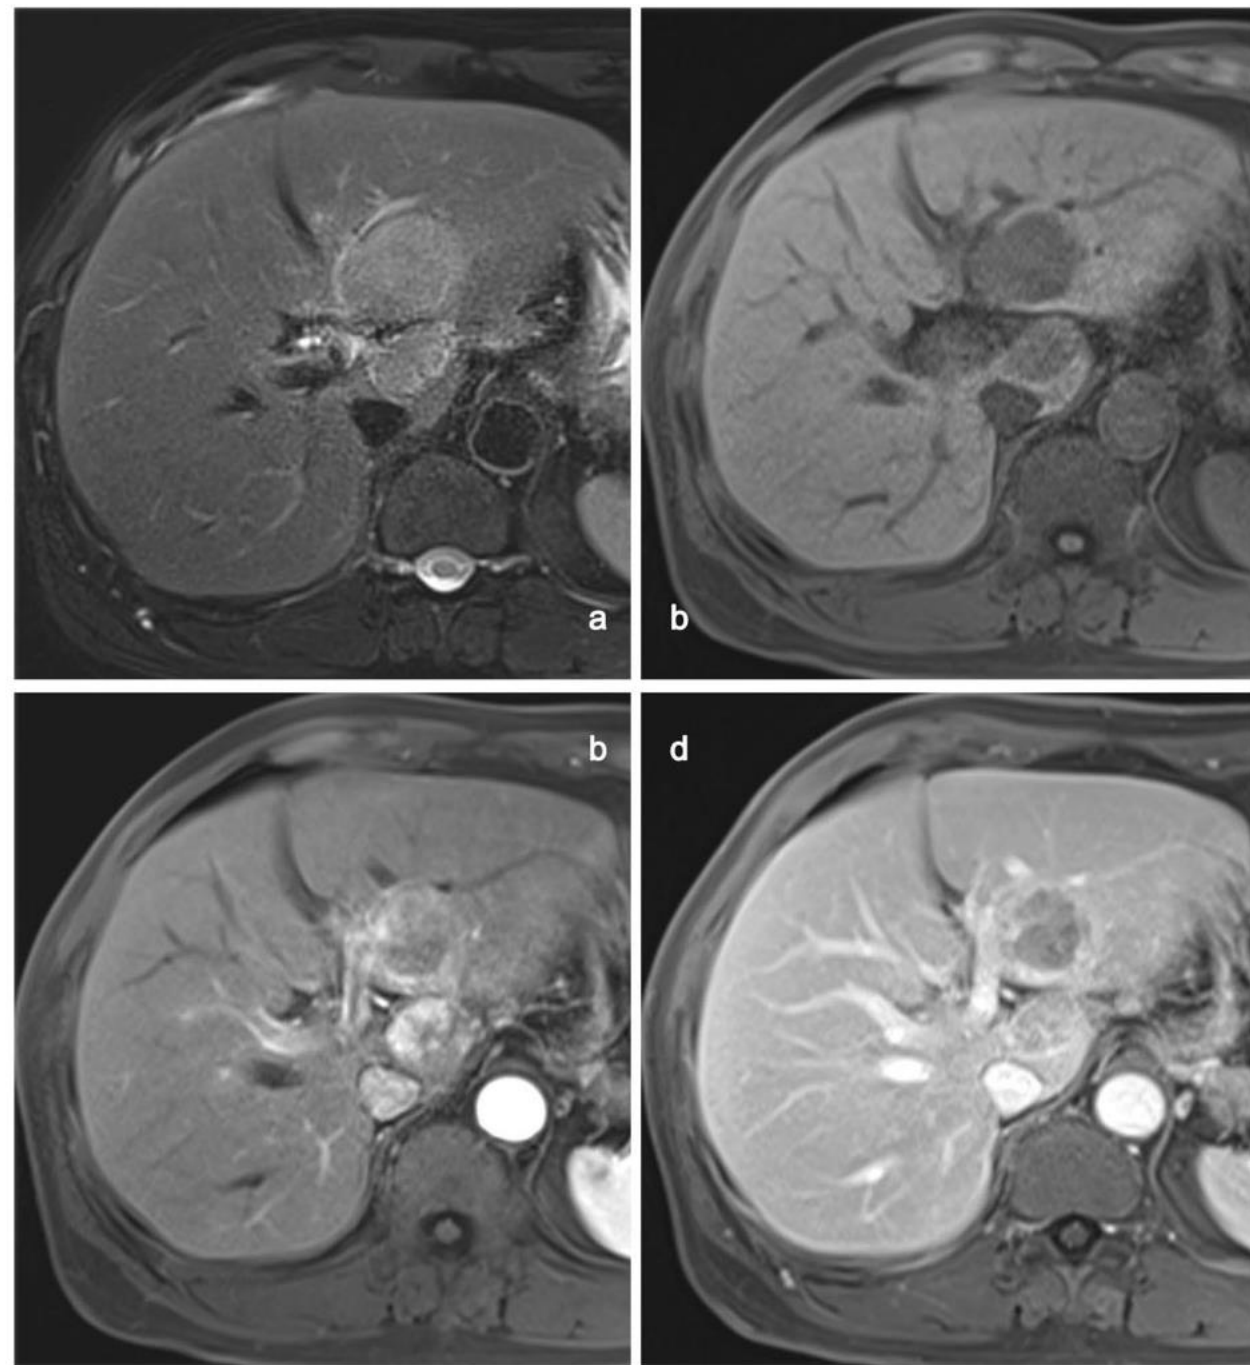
MR images in a 68-year-old man with classical ICC. Axial a T2-weighted, b precontrast T1-weighted, c arterial phase, and d portal phase gadolinium-enhanced MRI scans. Tumor (longest-diameter, 23 mm) with a lobulated margin exhibits hyperintensity on T2-weighted image (a), hypointensity on pre-contrast T1-weighted image (b), rim hyperenhancement on arterial phase image (c), and persistent enhancement on portal phase image (d). The area peripheral to the tumor shows wadgeshaped enhancement on postcontrast image (arrows in c and d). There is no biliary dilatation or liver capsular retraction. ICC Intrahepatic cholangiocarcinoma
